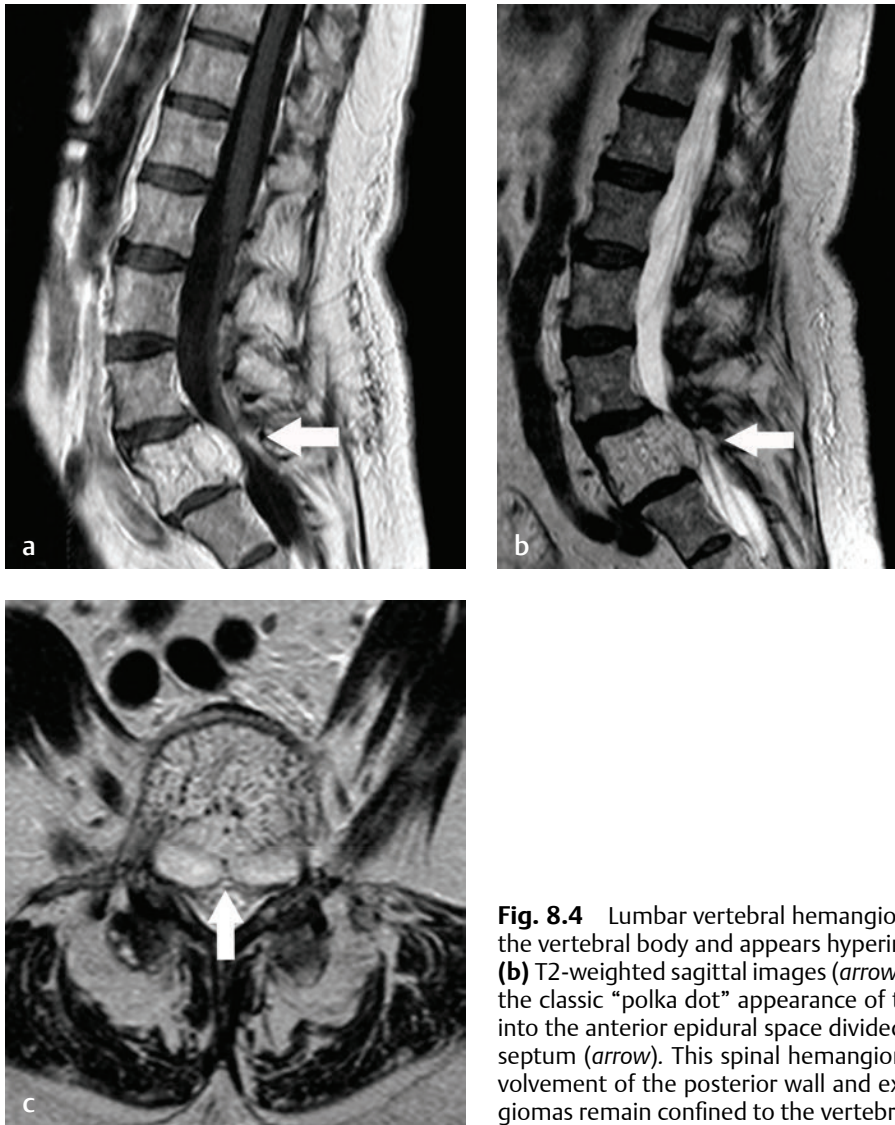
Lumbar vertebral hemangioma. This asymptomatic lesion is centered in the vertebral body and appears hyperintense on (a) T1-weighted postcontrast and (b) T2-weighted sagittal images (arrow on each). (c) On axial T2-weighted imaging, the classic “polka dot” appearance of the vertebral body is noted, with infiltration into the anterior epidural space divided by a cleavage plane formed by the midline septum (arrow). This spinal hemangioma is somewhat atypical in that there is involvement of the posterior wall and extension into the spinal canal. Most hemangiomas remain confined to the vertebral body.
